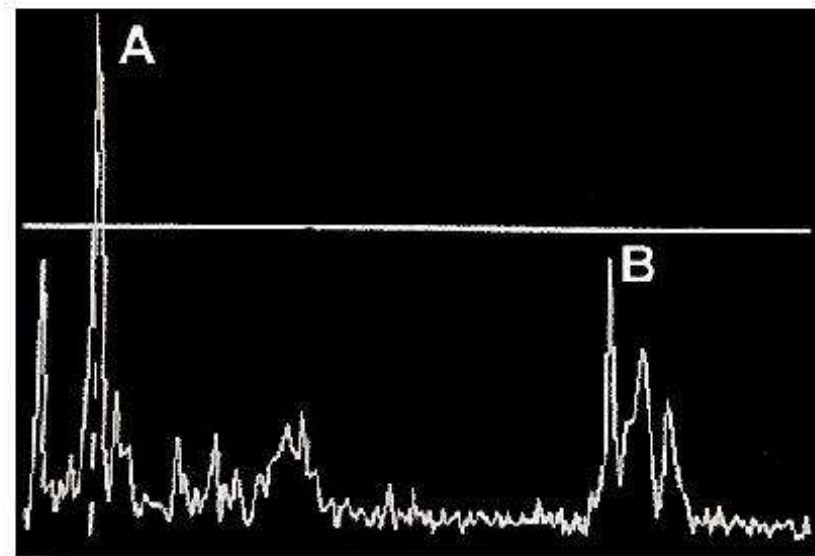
A sample A-mode ultrasound image
